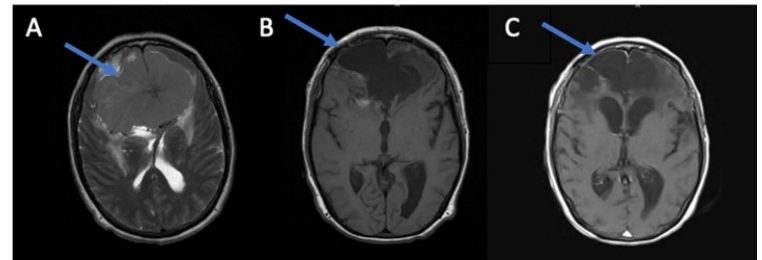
MRI showed: A) Large extra-axial mass centered in the anterior interhemispheric fissure exerting marked mass effect on the bilateral frontal lobes anteriorly and the anterior right temporal lobe. Mass was found to be a skull base meningioma and was subsequently resected. B) Postsurgical changes of mass resection from the anterior cranial fossa. No mass-like enhancement was seen to suggest residual tumor. Linear enhancement along the dura overlying the anterior left frontal lobe may represent continued postsurgical changes. C) Previous operative changes of frontal craniotomy with resection of a prior large interhemispheric meningioma. Postsurgical encephalomalacia, gliosis, and volume loss are unchanged from prior exam.
